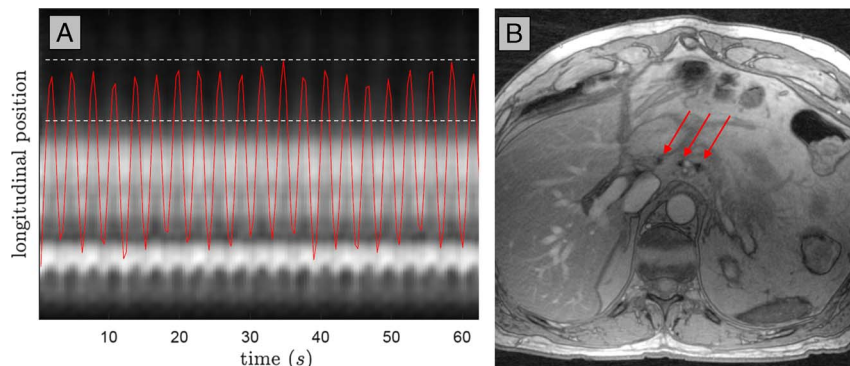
Motion-compensated USPIO-enhanced MRI at 3 T of the upper abdomen of a patient with esophageal cancer. During continuous breathing radial k-space sampling in a so-called stack-of-stars scheme allows detection of motion from a 1-dimensional projection of all signal in the head-foot direction (A). A compressed sensing reconstruction of all data in the expiration phase (periods in which the red curve is between the 2 dotted lines in A) provides a 3D image set in that phase, in which in 1 partition 3 healthy lymph nodes are visible as black dots (red arrows in B). Magnetic resonance imaging parameters: 3D T2*-weighted MRI with echo time 2.6 milliseconds (3 combined echoes), reconstructed resolution $1.15 \times 1.15 \times 1.25$ mm, acquisition time 4 minutes.
